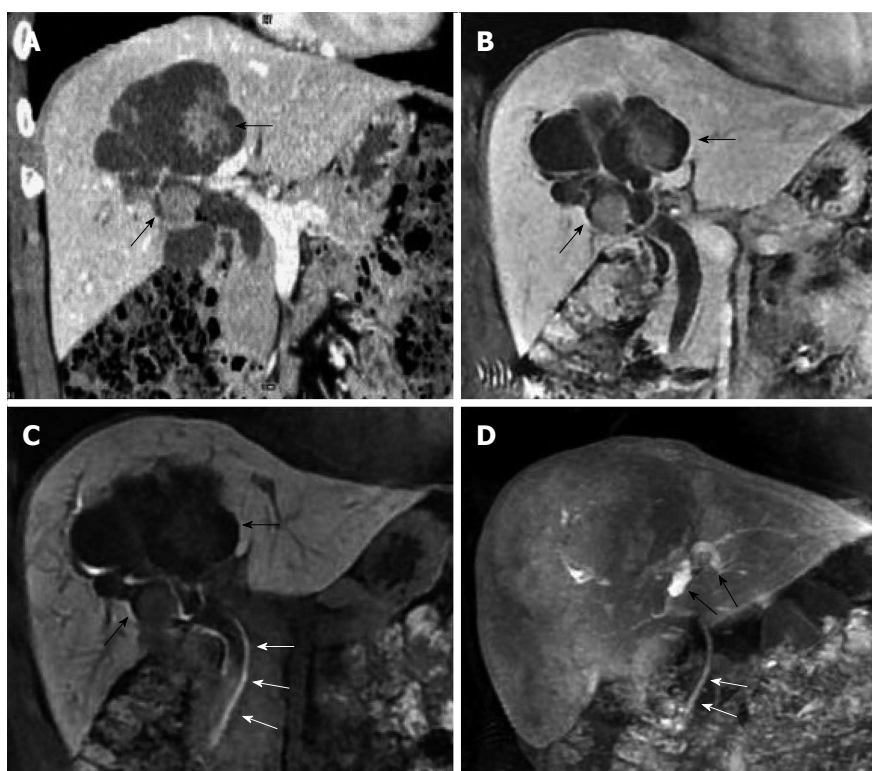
Fifty-two-year-old male patient with cystic intraductal papillary mucinous neoplasm of the bile duct (case 2). A: Coronal image of contrast-enhanced computed tomography; B: Gadolinium-ethoxybenzyl-diethylenetriamine-pentaacetic acid-enhanced magnetic resonance imaging (Gd-EOB-DTPA-enhanced MRI) in the portal venous phase showed extensive biliary and aneurysmal dilatations of the right intrahepatic bile duct, with multiple significantly enhanced masses within the lumen (black arrows); C: Gd-EOB-DTPA-enhanced MRI also showed a contrast-filling defect within the common bile duct (white arrows), suggesting the presence of mucin; D: Multiple planar reconstruction of images acquired in the hepatobiliary phase showed a dilated left intrahepatic bile duct with good contrast filling (black arrows). The contrast filling was incomplete in the right intrahepatic and common bile ducts (white arrows).
